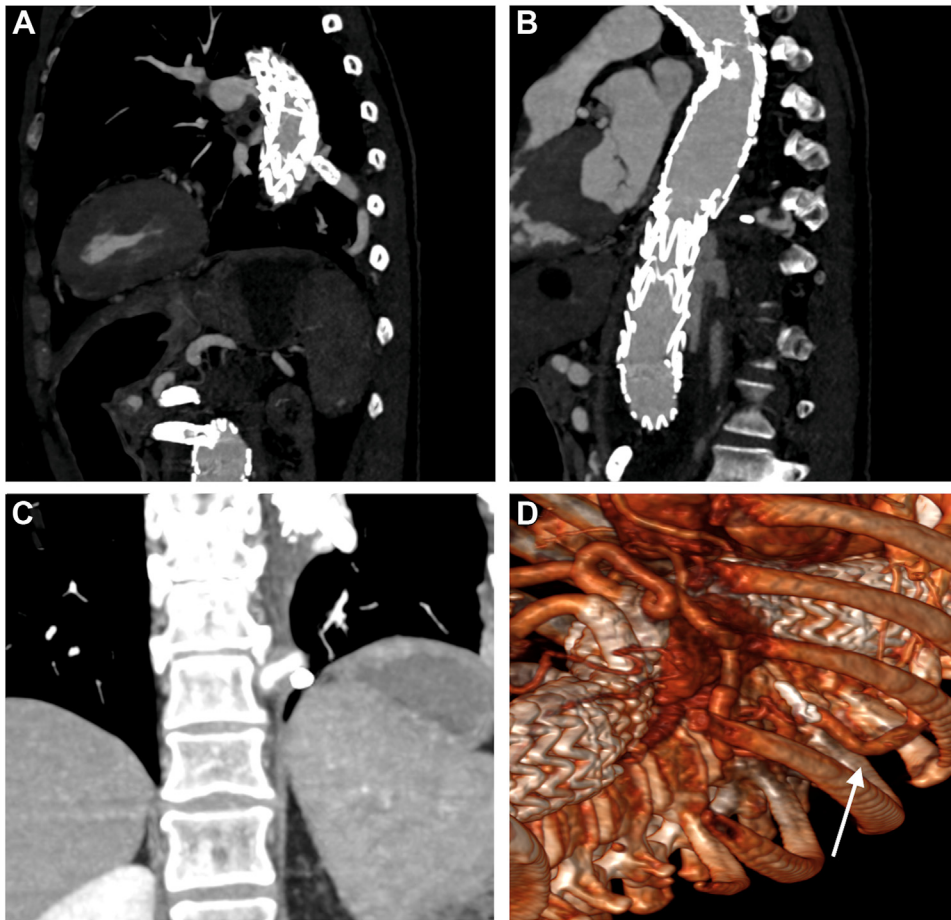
Postoperative computed tomography angiography (CTA) demonstrating patency of the bypass. A, Sagittal view of the proximal aspect of the bypass. B, Sagittal view of the distal aspect. C, Coronal view showing filling of the segmental artery. D, Three-dimensional reconstructed view demonstrating the patent bypass (white arrow).
